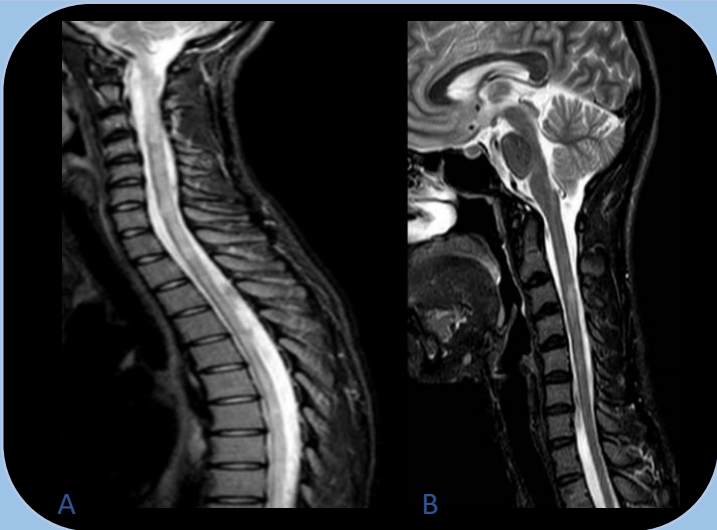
MRI (STIR, T2W) of patient 1 (A) and patient 2 (B)
